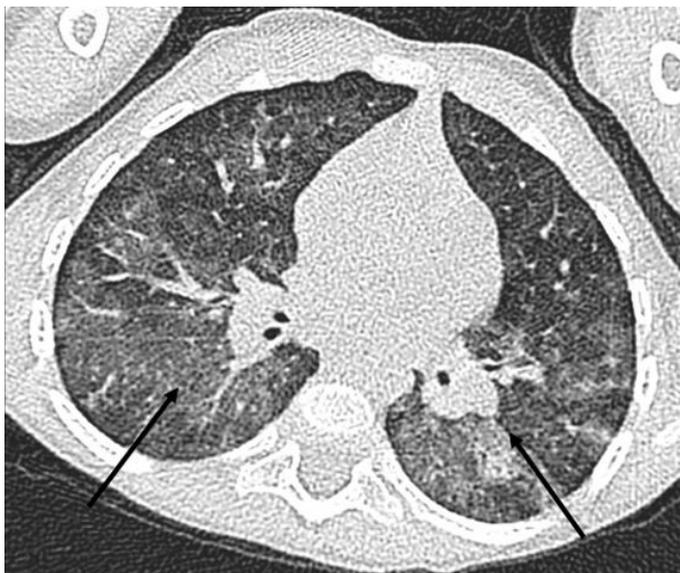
3 year old boy with idiopathic pulmonary haemosiderosis (IPH). Plain CT scan repeated 4 months after Figure 3. The transverse plane shows that the patchy ground-glass opacification has increased in intensity and extent. Dose length productivity (DLP) = 7, CTDIvol = 0.49, mAs=45.51 ms, kVp= 100 tube energy and slice thickness= 10mm.
